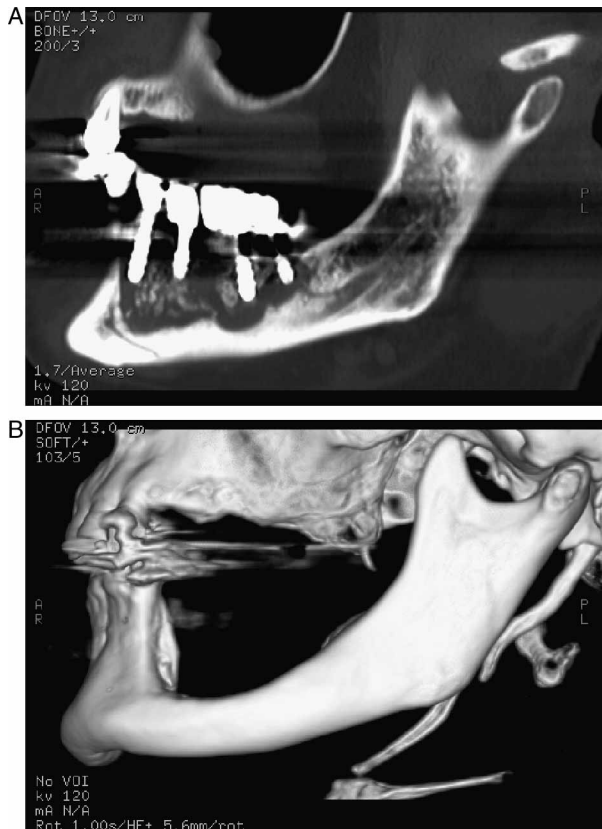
A. ONJ of the left hemi-mandible. CT oblique sagittal reconstruction displayed with bone window setting showing a large osteolytic lesion with a sequestrum in the site of four dental implants, B. Follow-up CT 3D reconstruction five months after surgical resection of necrotic bone.
